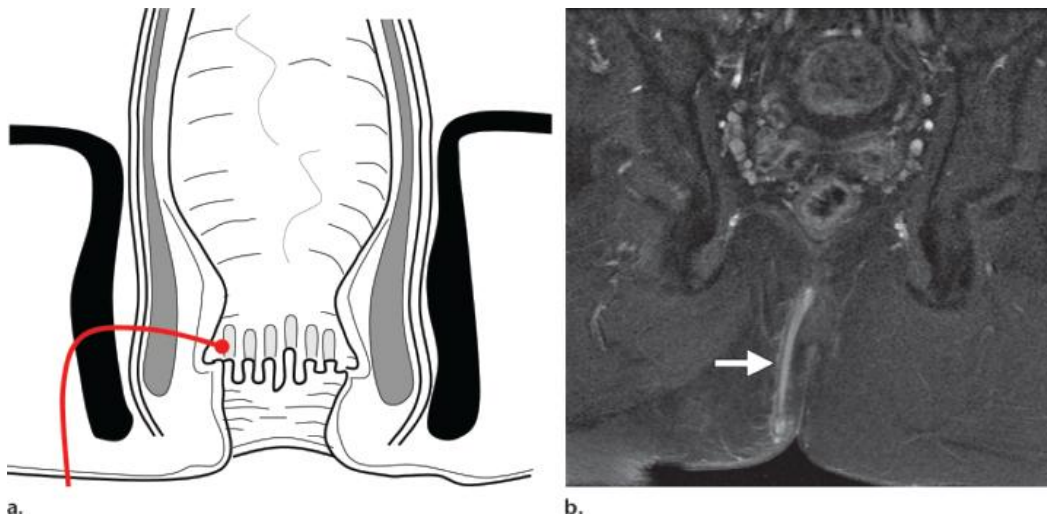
MR fistulogram of trans-sphincteric fistula. Axial T2-weighted MR image showing fistulous tract crossing external sphincter (arrow).
